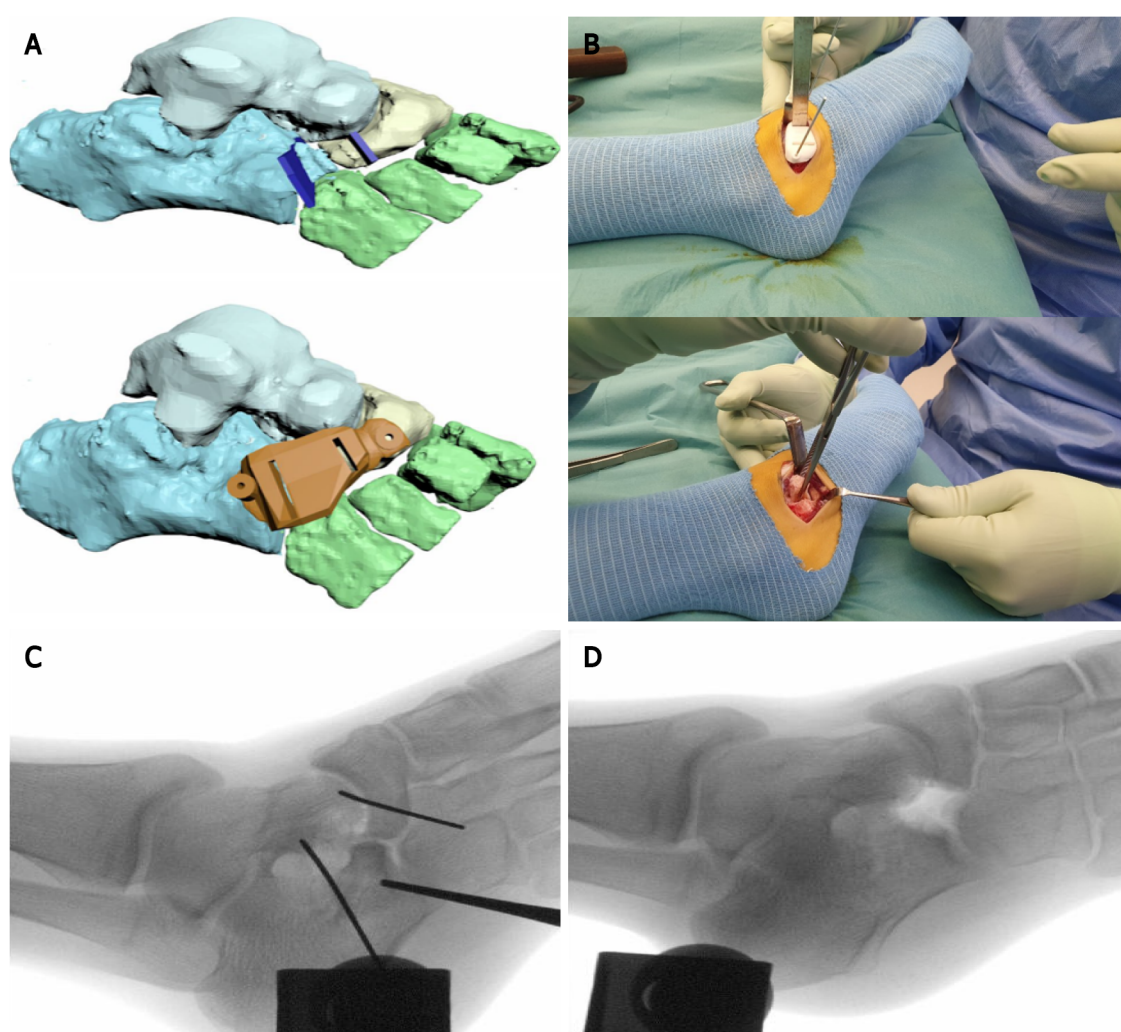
Preoperative planning and intraoperative use of three-dimensional-printing for a calcaneonavicular coalition in a 14-year-old girl. A preoperative magnetic resonance imaging scan was used to manufacture a three-dimensional (3D)-printed osteotomy guide for removal of a calcaneonavicular coalition. A: Preoperative 3D-planning; B: Intraoperative use of the manufactured 3D-printed guide and coalition resection; C: Intraoperative fluoroscopy shows the position of K-wires to hold the 3D-printed guide; D: Intraoperative fluoroscopy shows the resected bone.
